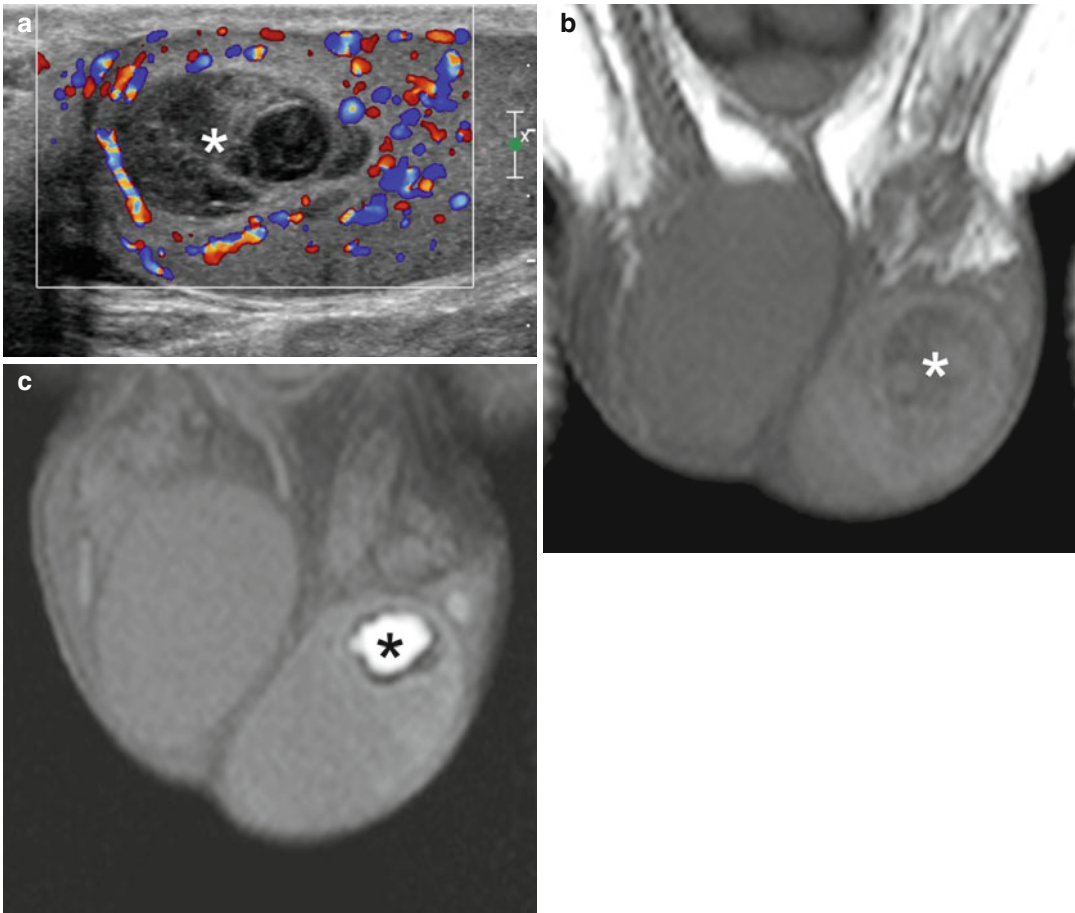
Spontaneous testicular hematoma. The patient presented with acute left scrotal pain for 3 h with no history of trauma. (a) Color Doppler interrogation shows an inhomogeneously hypoechoic left testicular lesion lacking vascularization (*asterisk*). (b) Coronal T1-weighted image obtained within 24 h after ultrasonography shows an
